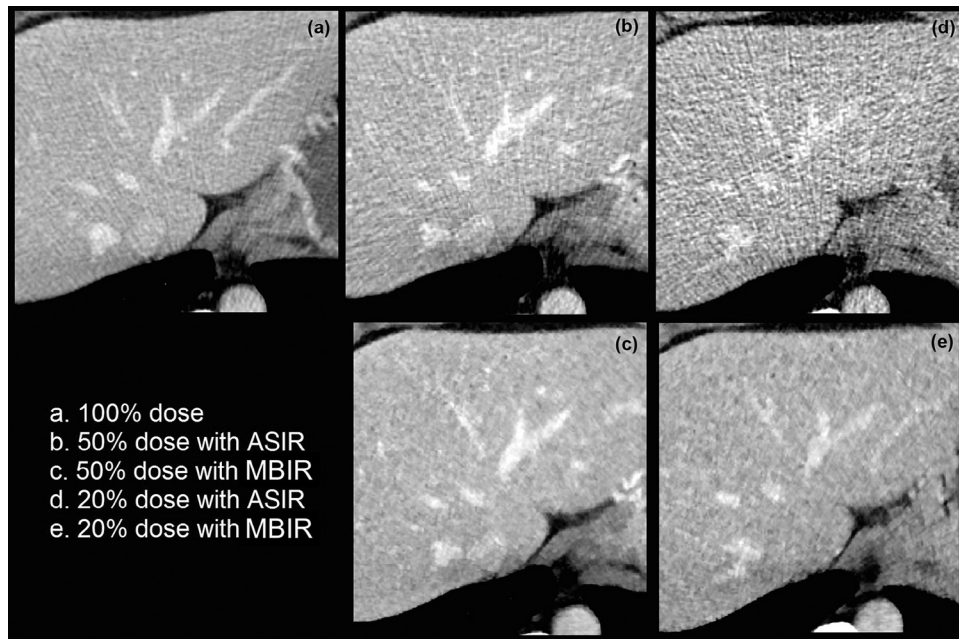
Side-by-side comparison of the intrahepatic veins for the reference 100% dose CT image (a) and two reconstruction algorithms and dose levels (b–e). Note the excellent image contrast of the hepatic vessels on (a) and (c), whereas image noise hampers the contrast on (b) and (d). ASIR, adaptive statistical iterative reconstruction; MBIR, model-based iterative reconstruction.
